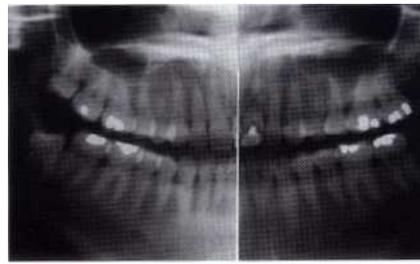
Preoperative Panorex radiograph of tooth #9, which requires extraction and a single tooth implant.
